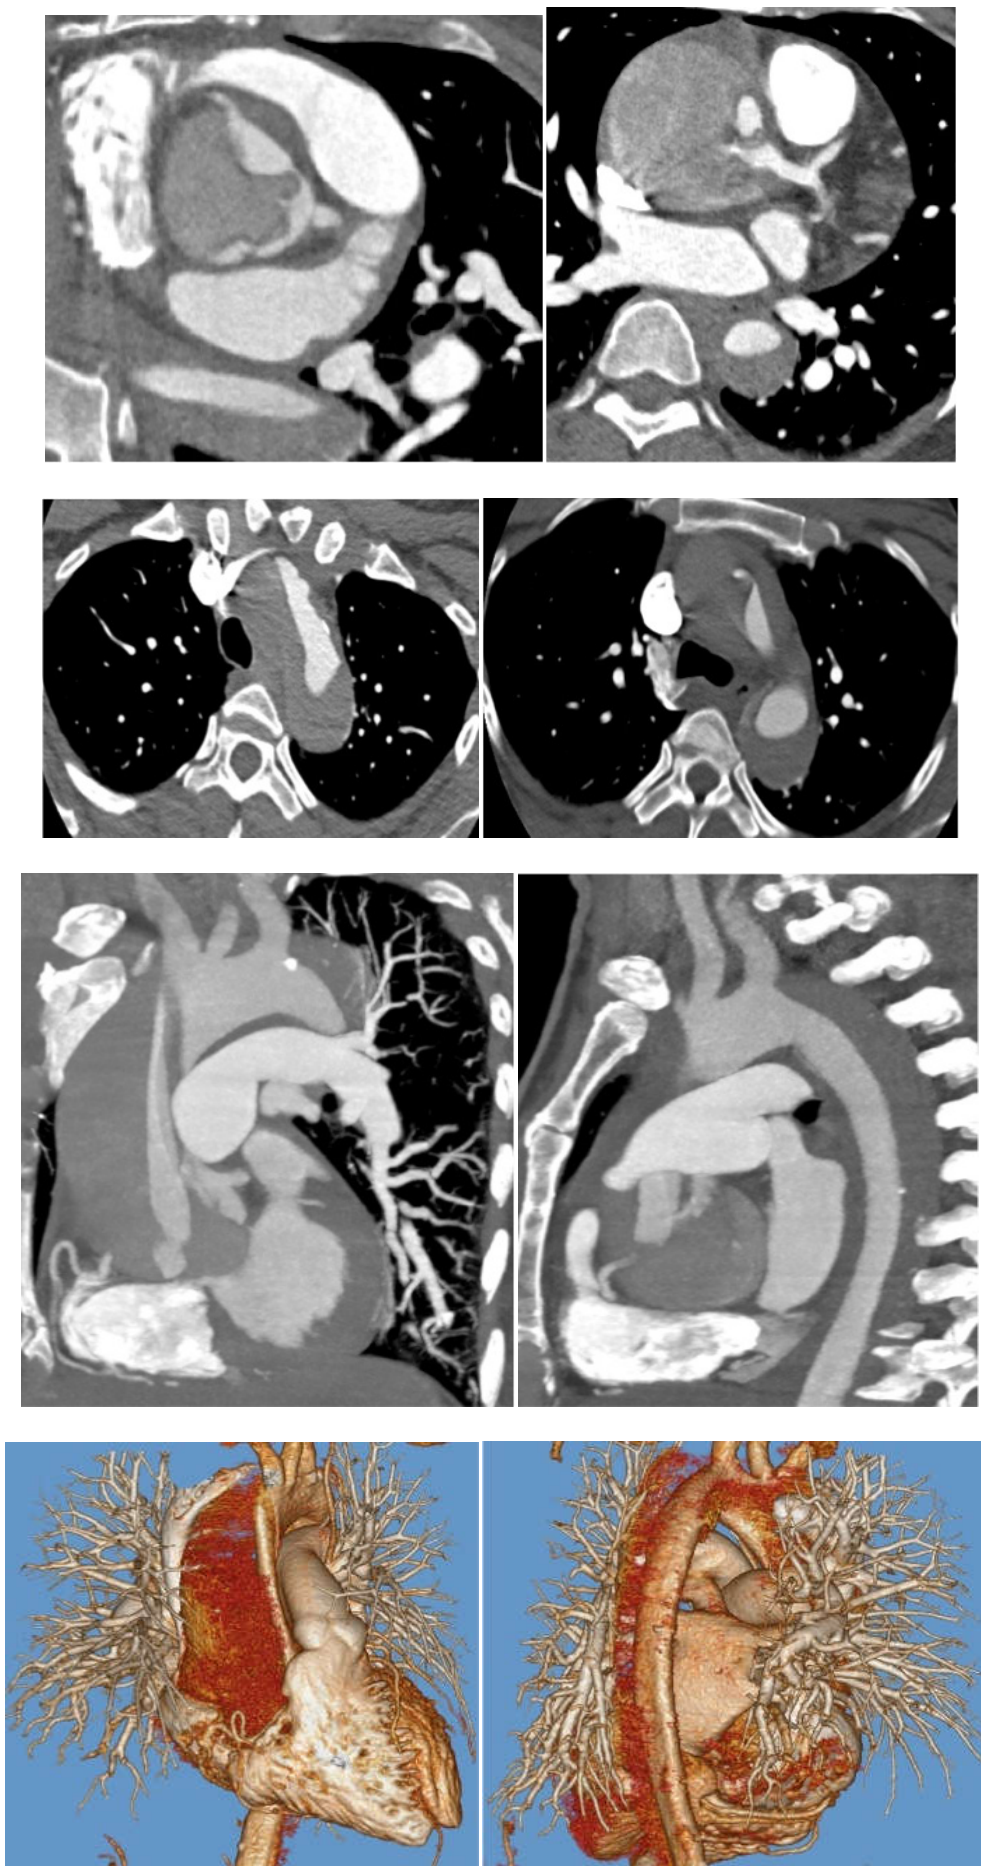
TRO CT angiogram in 34-year man with recent onset of vague chest discomfort. TRO CT MPR Axial image (a,b), Coronal (c,d), Sagittal (e,f), 3D images (g,h,i) and virtual aortic angiography (j) demonstrates Stanford type A aortic dissection involving ascending aorta, arch& descending aorta. Extending into the abdomen
